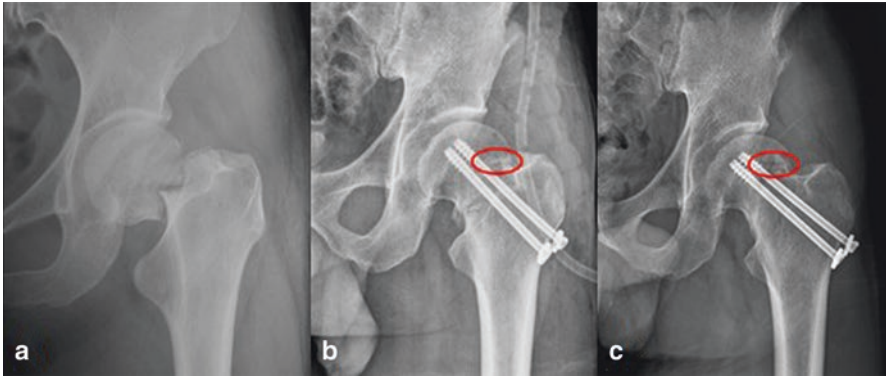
(a) Preoperative radiographs of a 35-year-old male patient with Garden III fracture; (b) the fracture was fixed with magnesium screw (red ring) and two cannulated screws and vascularised iliac grafting; (c) 12 months postoperative radiographs showing the fracture healing and magnesium screw (red ring) [116]
